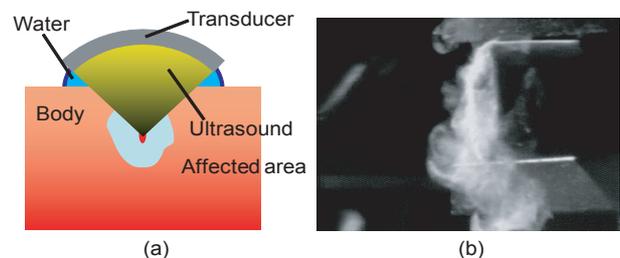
(a) High-intensity focused ultrasound (HIFU). (b) Destruction of kidney stone by HIFU.
